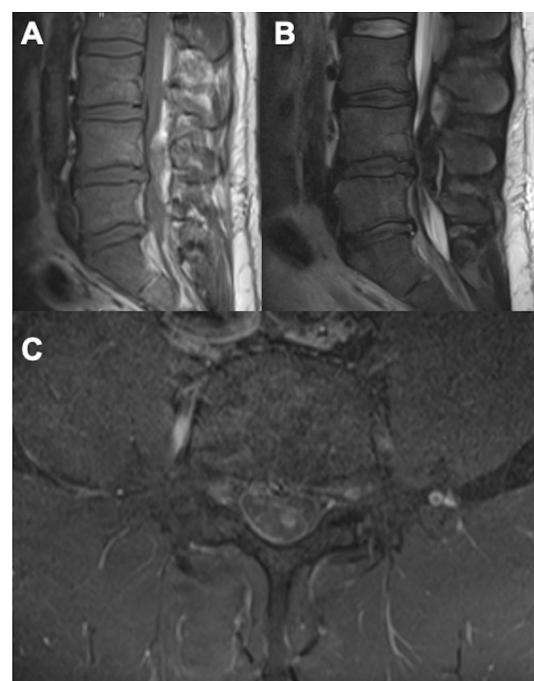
Lumbar spine MRI. (A) Sagittal T1 MRI shows an L4-5 large dorsal compressive epidural lesion, with heterogeneous intensity. (B) Sagittal T2 MRI shows the same lesion (arrowhead) which appears hypointense with severe canal stenosis and compression of the thecal sac. (C) Axial MRI with contrast (gadolinium) reveals enhancing capsule surrounding the non-enhancing mass (arrow). This was thought to be a haematoma versus haematological malignancy.
